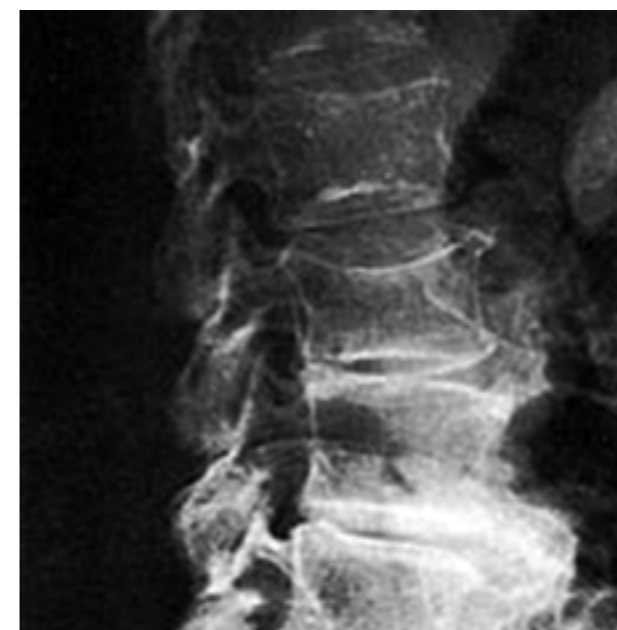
X-ray of the thoracic and lumbar spine and skull dated September 26, 2005: wedge-shaped deformity of Th12 bodies, rounded defects in the skull vault area
